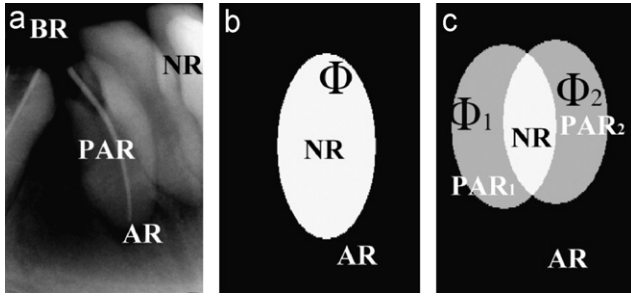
Region modeling. (a) The dental X-ray image can be divided into four regions: Ω_{NR} , Ω_{PAR} , Ω_{AR} , and Ω_{BR} . (b) With one curve C , one level set function segments the image into Ω_{NR} and Ω_{AR} . (c) Two competitive coupled level set functions segment the image into three regions: Ω_{NR} , Ω_{PAR} and Ω_{ABR} .
